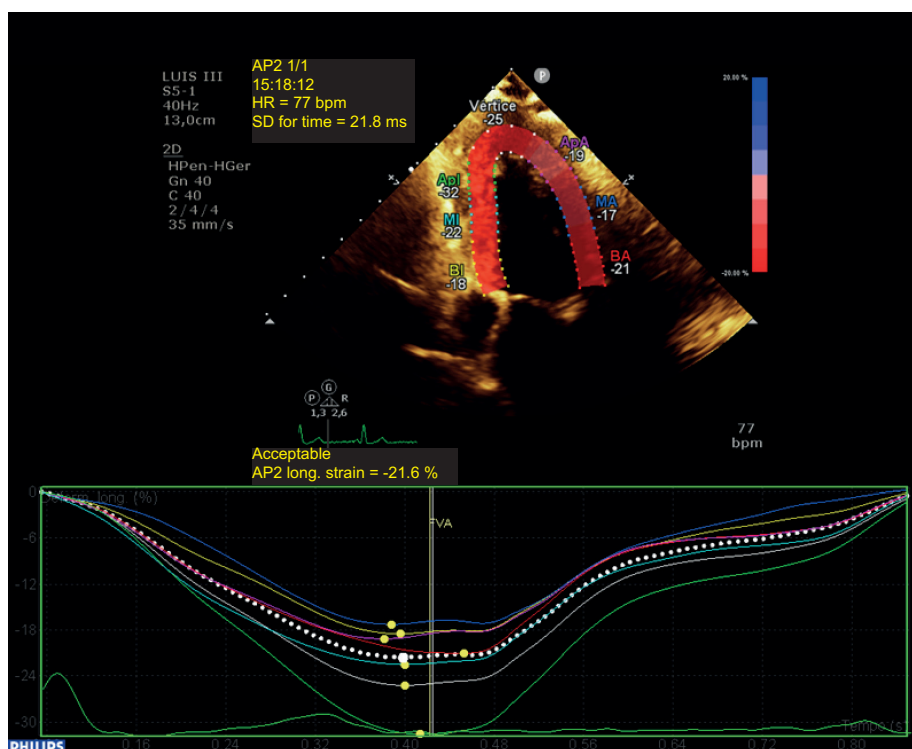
Two-chamber apical longitudinal strain of the second echocardiogram with normal values and without post-systolic contraction.
